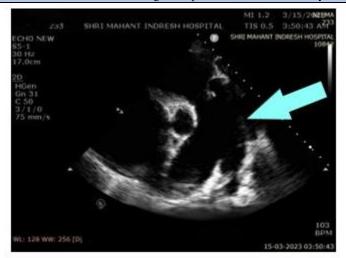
(c) – Transthoracic short axis view at arterial level showing dilated pulmonary artery with PA to Aorta ratio of 2.8.
